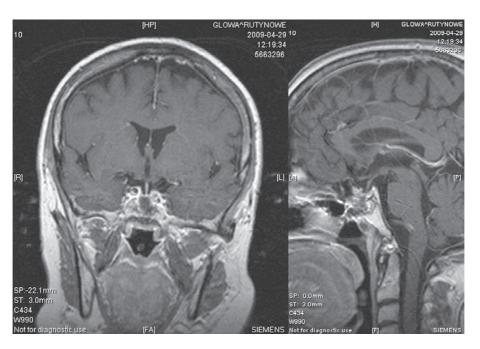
The MRI of the sellar region performed in 2009 (2 years after the repeat surgery). A. Frontal section; B. Sagittal section Rycina 1. Zdjęcia rezonansu magnetycznego okolicy siodła tureckiego wykonane w 2009 roku (2 lata po powtórnej operacji przezklinowej). A. Przekrój czołowy; B. Przekrój strzałkowy
